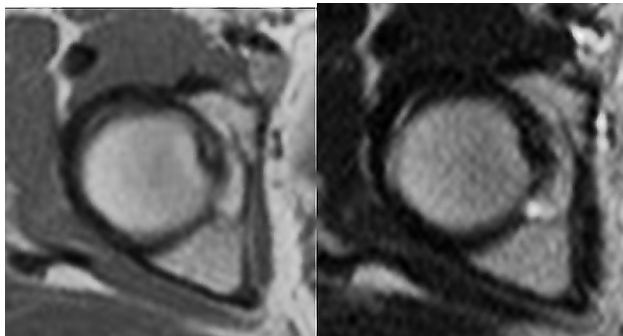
Magnetic resonance imaging, T1 and T2 weighting.
